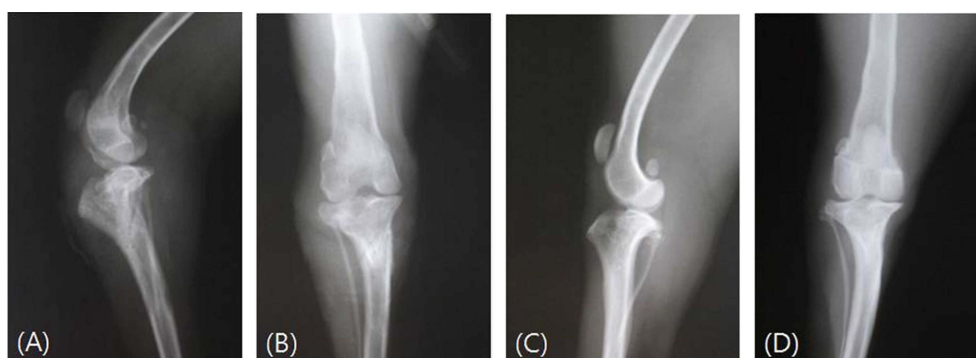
Post-operative radiographic view after 6 weeks. The fracture was healing well and the implants were removed (A and B). After 7 months, the fracture site was completely healed and the physis was closed (C and D).
